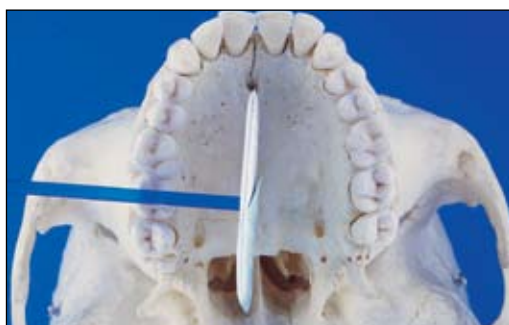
Path of the X-rays in a standard projection.
